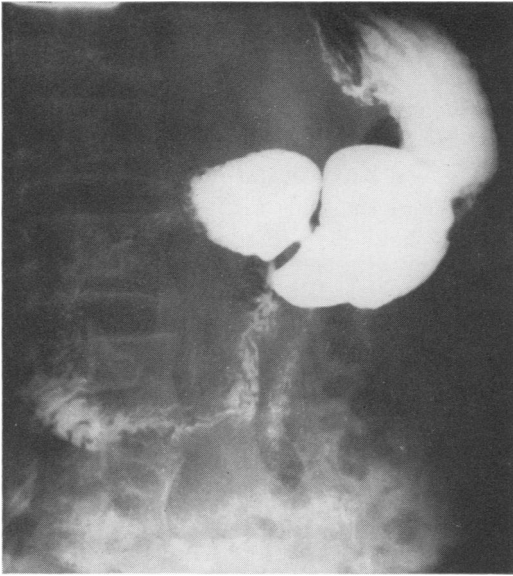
Case 2. X-ray of abdomen showing extravasated media in left subphrenic space and catheter for sump suction.
